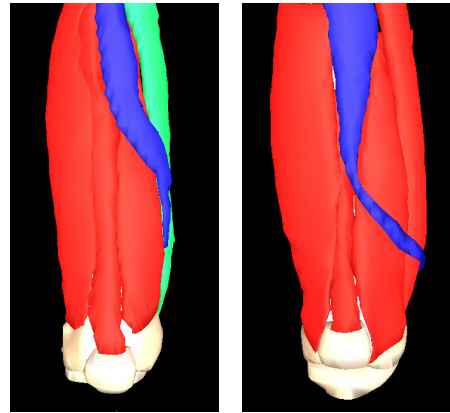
Reconstruction of muscle-tendon geometry from MRI. Anterior view of the transferred rectus femoris (blue), vasti (red), sartorius (green) and bones (white) of the right lower limbs are shown for Subject 1 (left panel) and Subject 4 (right panel).
